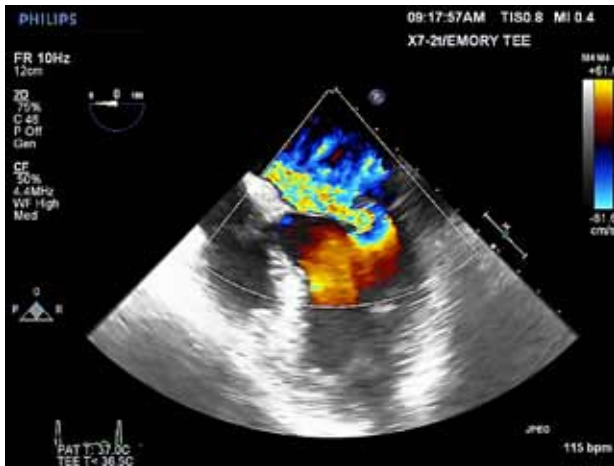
Transesophageal echocardiography, 4-chamber view with color Doppler, showing a large mitral regurgitation jet directed anteriorly.
